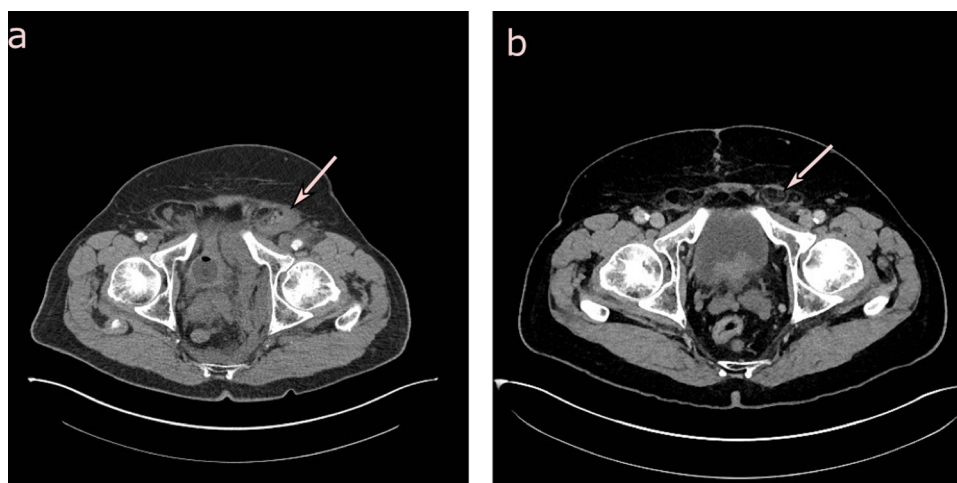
(a) Preoperative CT angiography showing a bilateral dilated inguinal canal containing hernia with surrounding fat—on the left side with haematoma/blood (arrow). (b) Postoperative CT angiography showing the bilateral dilated inguinal canal with hernia content (arrow).
